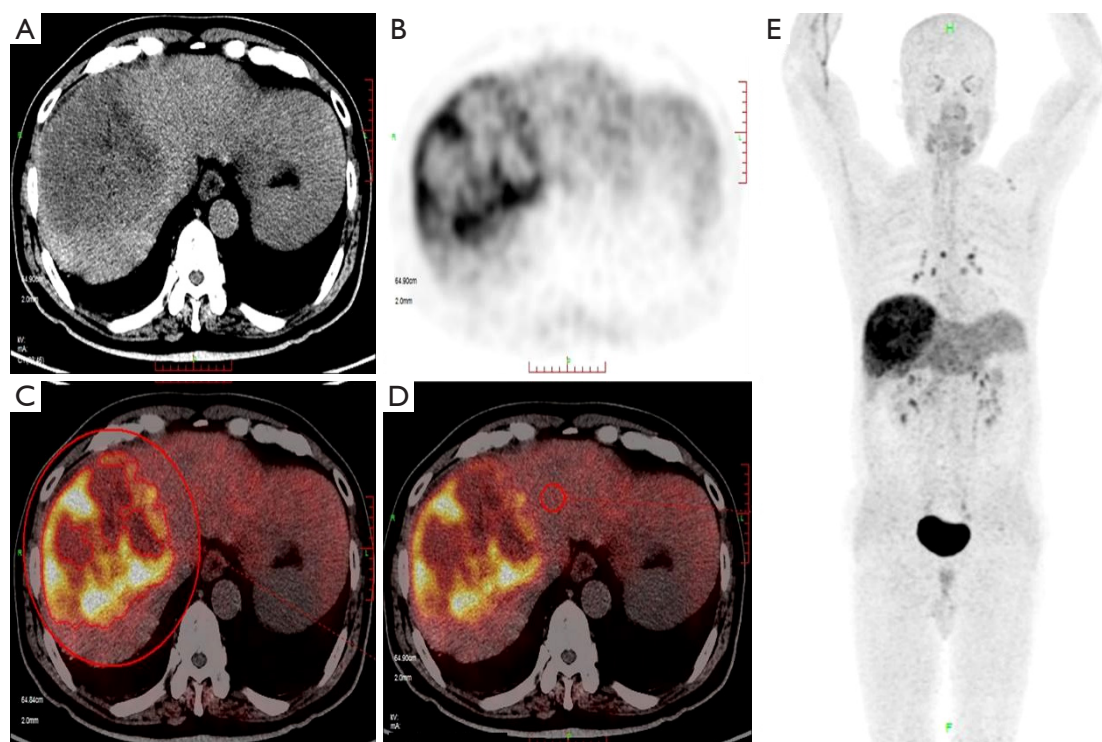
ROI of the liver tumor and normal liver tissue in ^{18}F -FAPI-42 PET/CT. (A,B) The axial images of CT and PET. (C,D) Fusion PET/CT images for the ROI of hepatic lesions obtained with the three-dimensional sketching method (the bigger red circle) and the ROI of normal liver parenchyma (the smaller red circle) using the fixed area method (area of 3 cm^2). Semiquantitative parameters were obtained automatically. (E) The maximal intensity projection image. ROI, region of interest; ^{18}F -FAPI-42 PET/CT, Fluor 18 (^{18}F)-conjugated fibroblast-activation protein inhibitor (FAPI-42) positron emission tomography-computed tomography; CT, computed tomography; PET, positron emission tomography.
